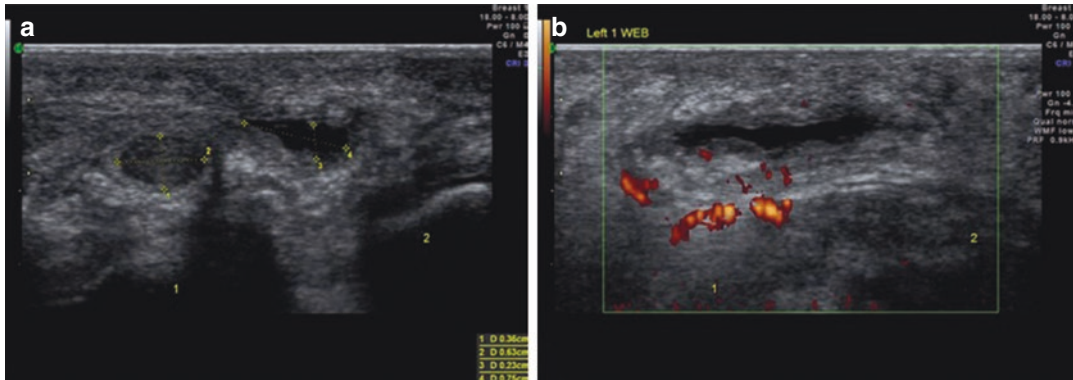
Shearing force induced inflamed bursal sac targeted for image-guided injection. (a) Transverse scan shows web space cystic area. (b) Doppler longitudinal
